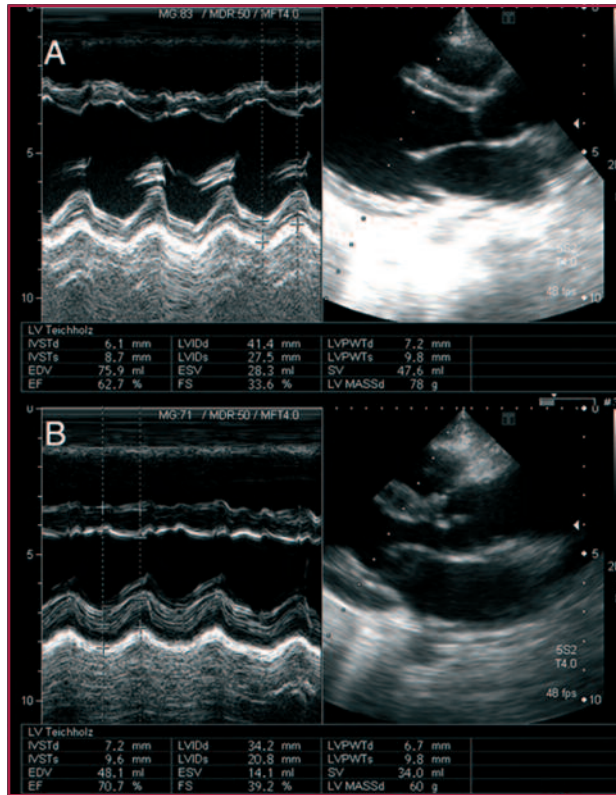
Transthoracic echocardiographic measurements. A. Pre-operative. B. One-year postoperative control
